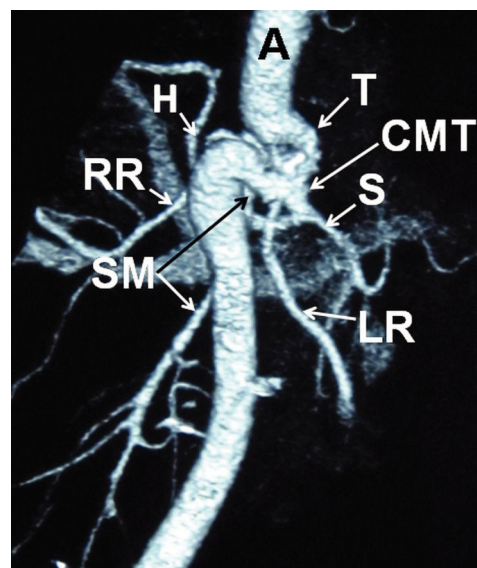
3D computed tomography (CT) angiography. A = aorta; T = tortuosity; H = common hepatic artery; S = splenic artery; CMT = common celiacomesenteric trunk; SM = superior mesenteric artery; RR = right renal artery; LR = left renal artery.
